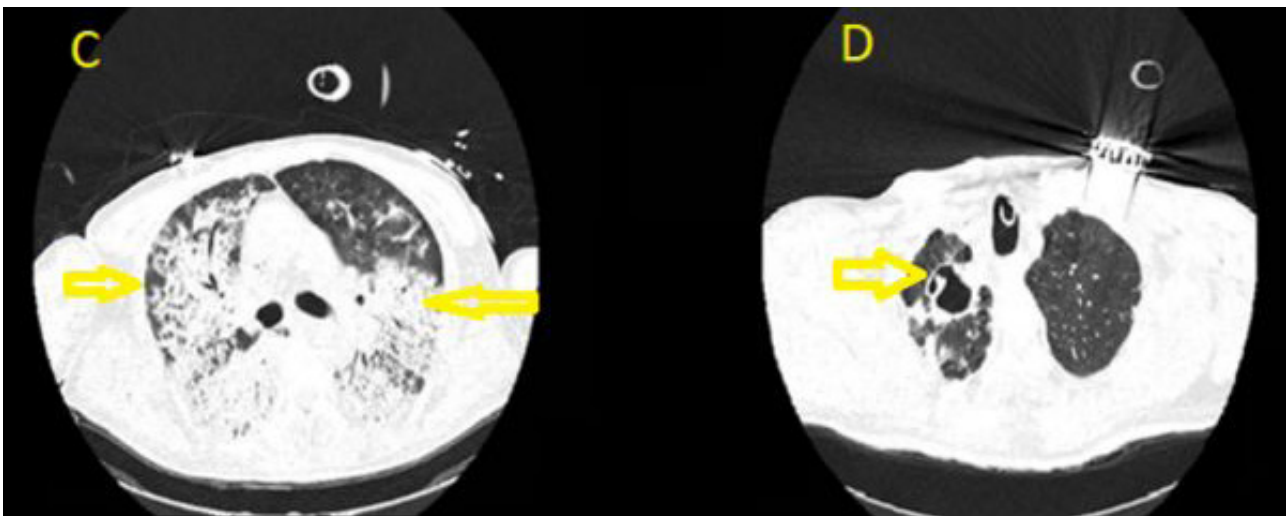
Thoracic computed tomography images showing a widespread consolidation with central and peripheral distribution bilaterally, These findings are suggested of diffuse alveolar hemorrhage (C), also a cavitory lesion seen in right pulmonary apex (D).
